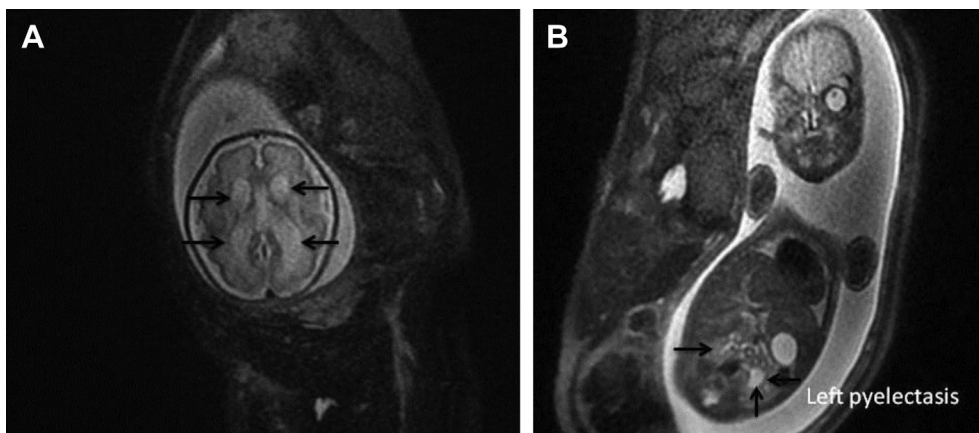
Magnetic resonance imaging analysis at 31 weeks of gestation shows (A) mild dilation of bilateral lateral ventricles (arrows) and (B) left pyelectasis and a normal right kidney.
